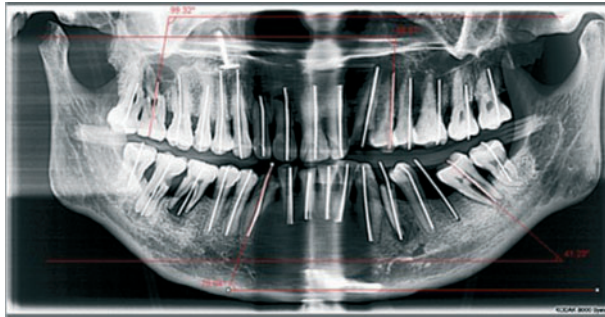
Radiograph of skull apparatus with examples of the measured Mesiodistal ascal inclination
